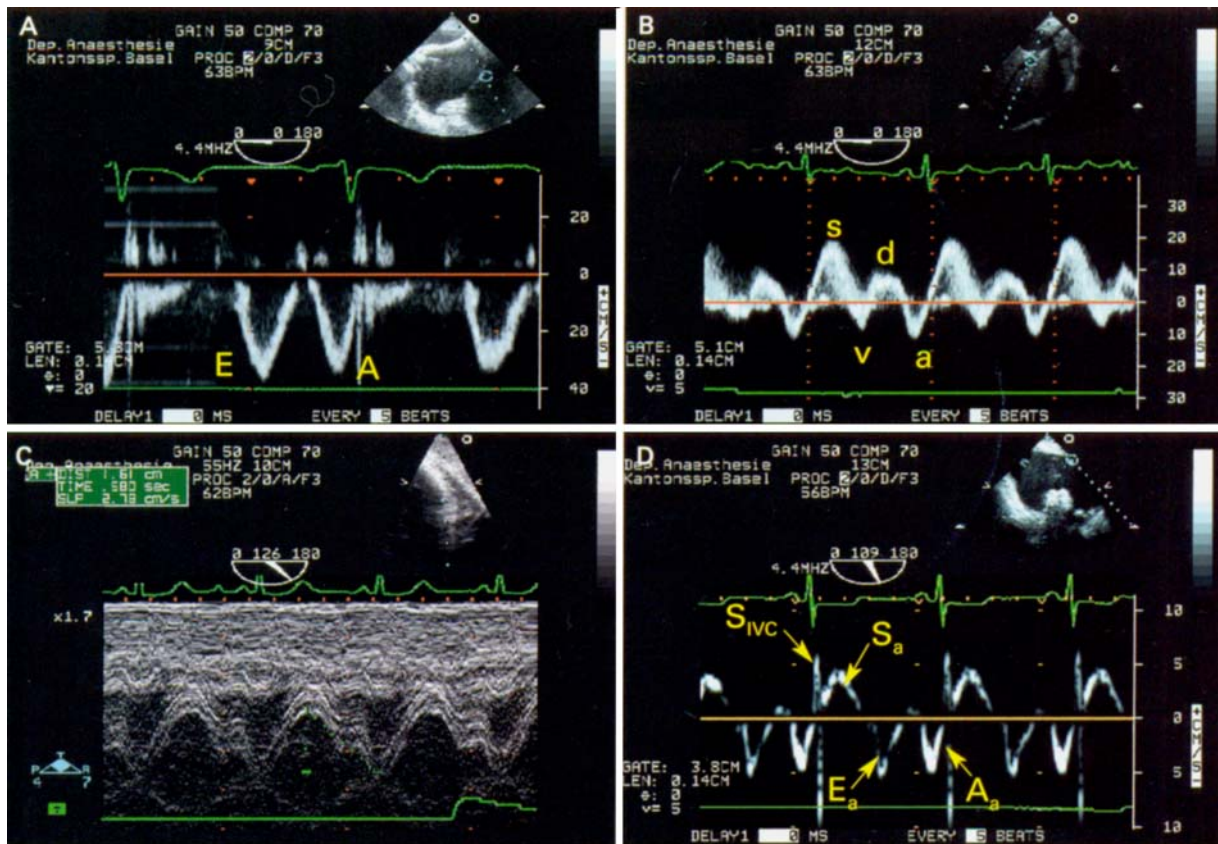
Doppler and M-mode examination of the right heart. (A) Tricuspid inflow, with early (E) and late (A) waves shown. (B) Hepatic venous flow: a = atrial reverse wave, d = diastolic wave, s = systolic wave, v = late systolic reverse wave. (C) Tricuspid annular plane systolic excursion, measured in M-mode on the transgastric right ventricular inflow (TG RV inflow) view. (D) Tissue Doppler imaging of the tricuspid lateral annulus: A_a = atrial myocardial wave, E_a = early myocardial diastolic wave, S_a = systolic myocardial wave, S_{IVC} = isovolumic contraction.
